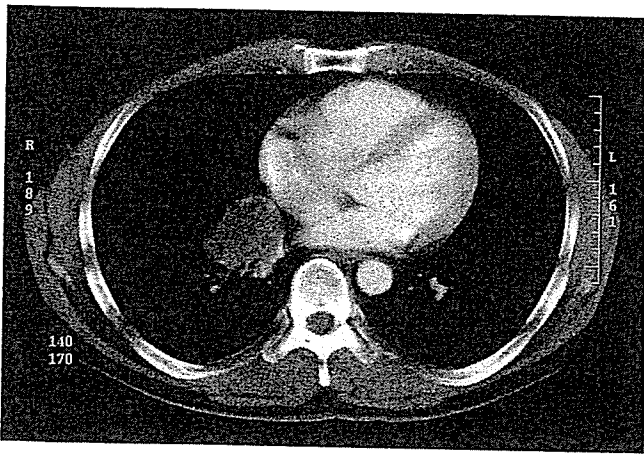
Chest computed tomography scan showing a mass in the middle and lower lobe that is partly necrotic
